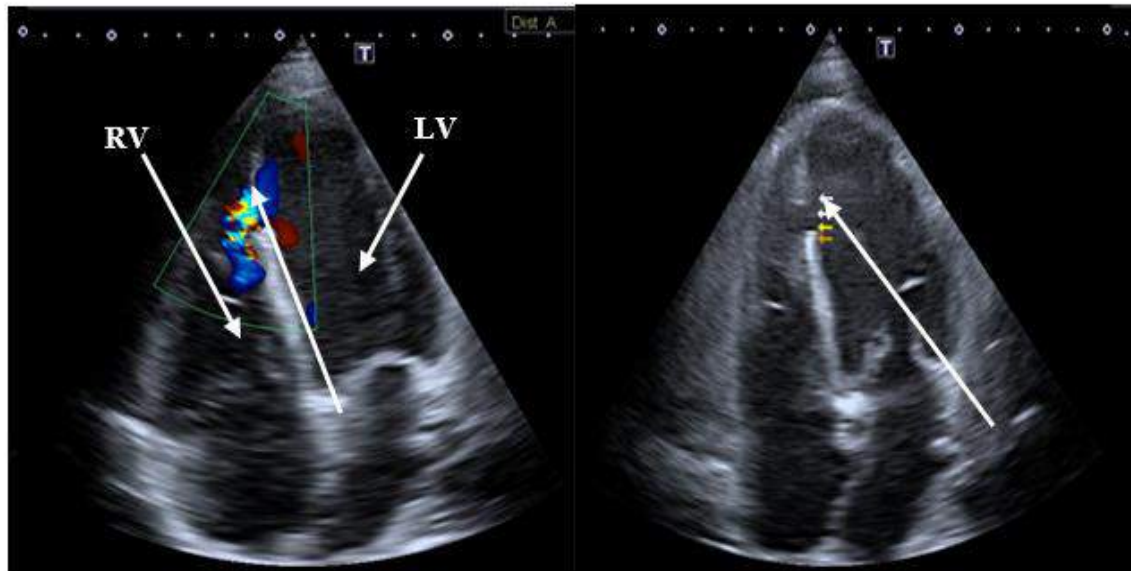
2D Echocardiogram demonstrating VSD located at the apex with left to right shunt
